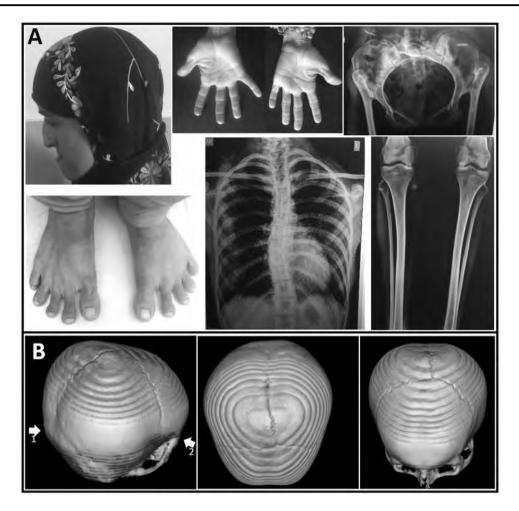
Findings in patients. a Pictures and X-ray images of affected sib 502. Clockwise from upper left: mandibular prognathia, maxillary hypoplasia, and prominent nose bridge; thin cylindrical fingers with extra ventral phalangeal creases and shortening of fifth fingers; hypoplasia of pelvic girdle with short iliac wings, malformation of acetabula and asymmetrically and posteriorly dislocated femoral heads that articulated with the posterior aspects of iliac crests; narrowly aligned tibiae and fibulae, and hypoplastic and malpositioned patellae; general osteopenia and lack of maturation of tubular bones as
